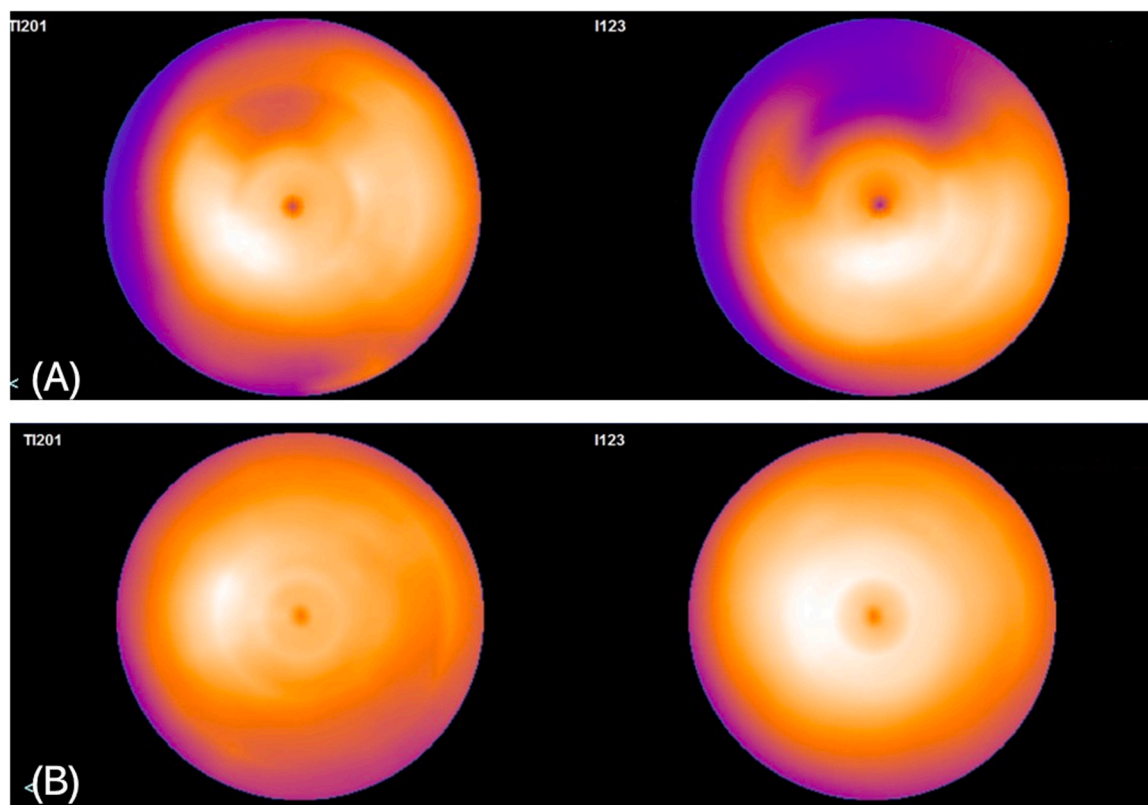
Simultaneous binuclear myocardial scintigraphy of thallium and BMIPP images on the 11th day and 4 months later. A mismatch between thallium and BMIPP was observed in the anterior wall region, but not in the apical region (A). The blood flow/metabolic mismatch observed during the acute phase disappeared during the chronic phase (B).
